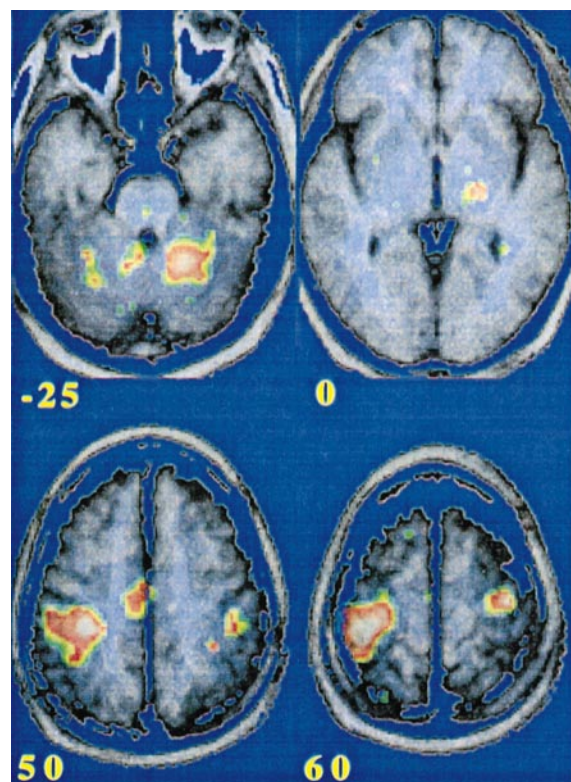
PET/MRI superimposition. PET data for *t*-values during left finger movements displayed on the same colour scale as for Fig. 3. Images are horizontal sections positioned from -25, 0, 50 and 60 mm above the bicommissural (CA-CP) plane.
